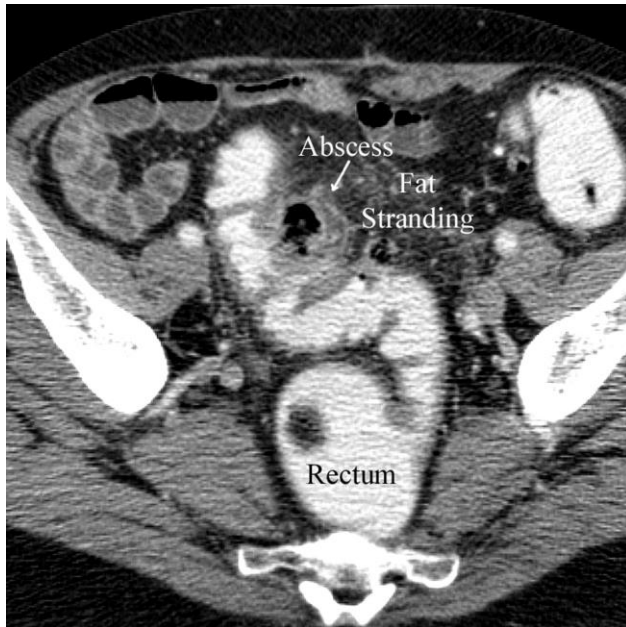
Diverticulitis in a 62 year old man with lower abdomen and pelvic pain. Axial CT performed with rectal contrast shows sigmoid colon wall thickening, pericolic fat stranding, and a pericolic abscess.
